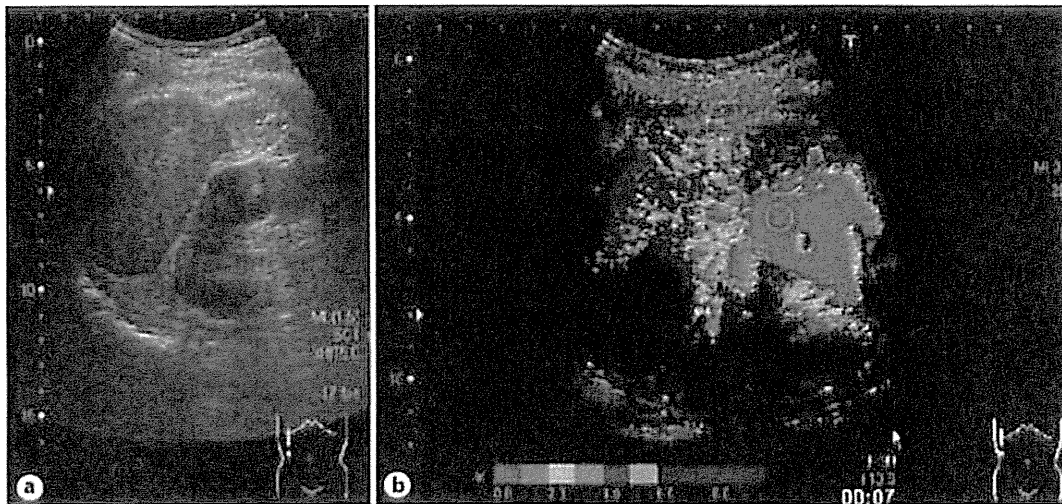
Ultrasound images of case 1 taken in July 2010. a B-mode ultrasound image. b Arrival time parametric image. Blue, indicative of late arrival, dominated the entire area of the arrival time parametric image of the liver.
